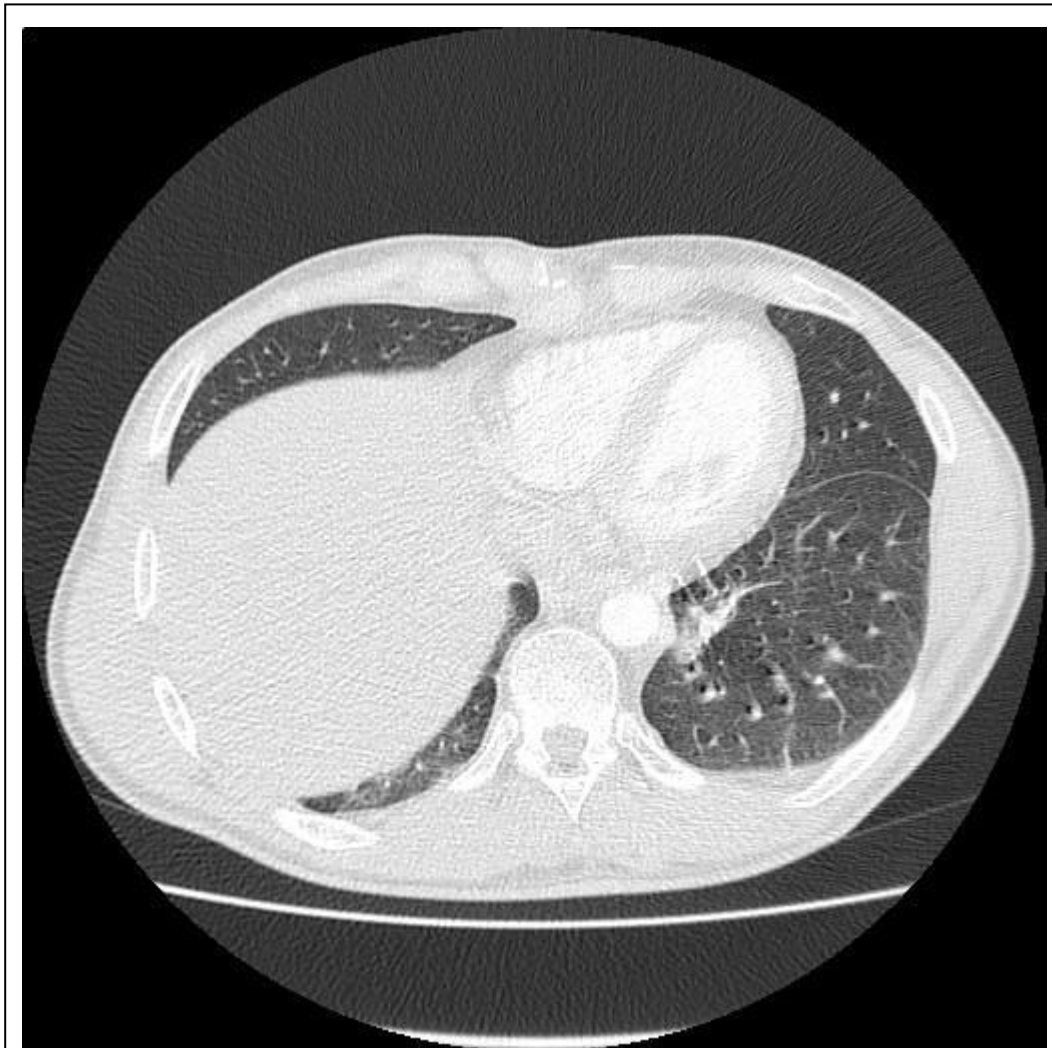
Six months CT control.
